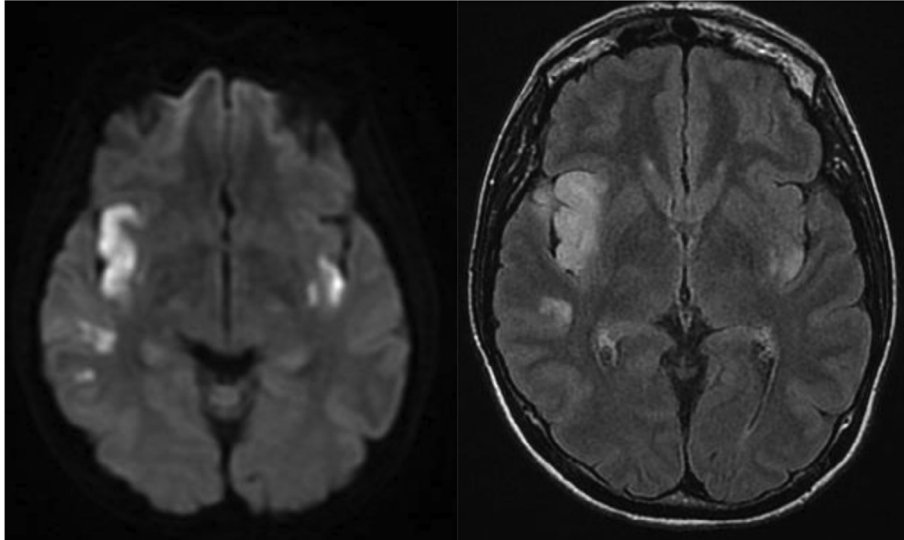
MRI scan; on the right FLAIR sequences showing abnormal hyperintense signaling in the right insular lobe and smaller similar lesions in the right temporal lobe and in the contralateral insular lobe. These alterations are characterized by a marked restriction in the DWI sequences (left), which is consistent with the acute vascular origin.
